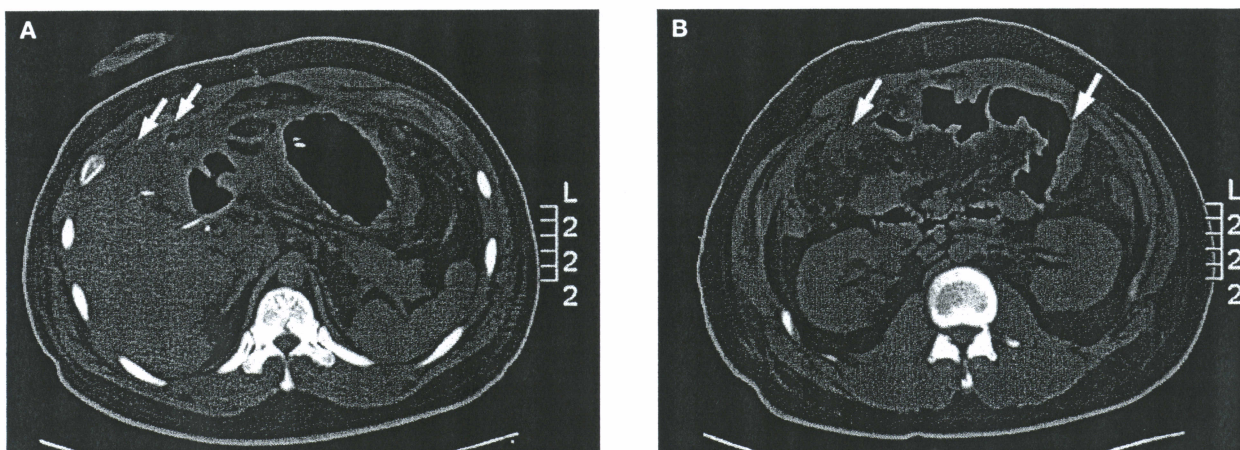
Abdominal computed tomography scan showing a pneumoperitoneum (arrows) [A] and a small amount of ascites, dilated small bowel loops, edematous colon wall, and increased infiltration at the mesentery (arrows) [B].
